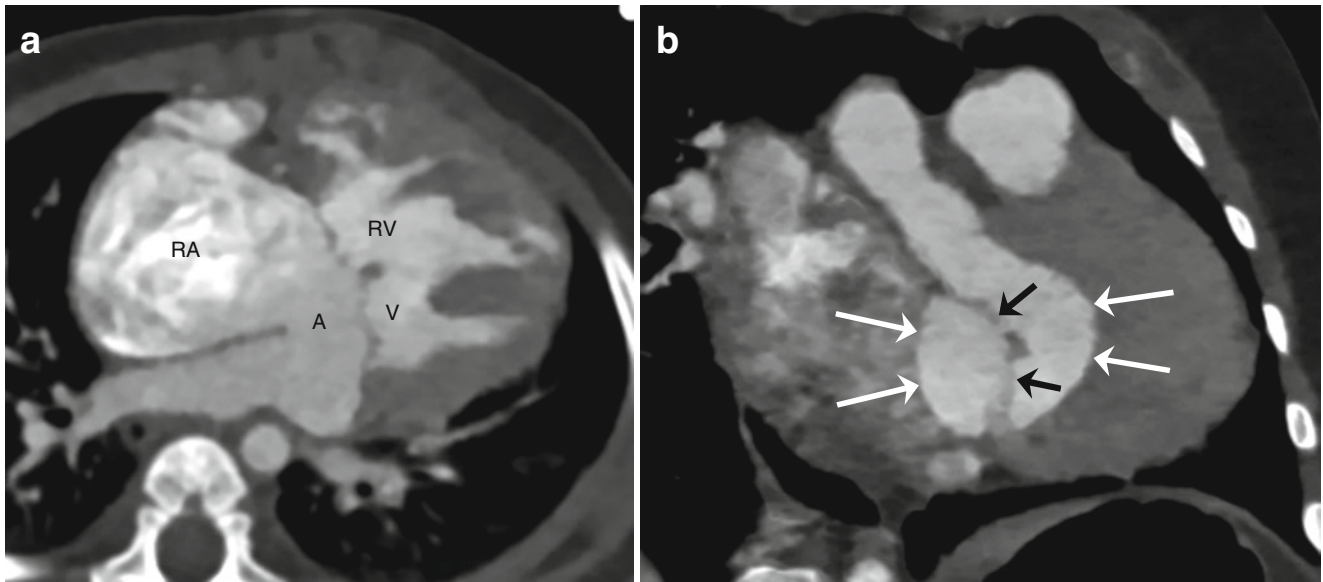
Atrioventricular septal defect. Four-chamber CT image shows an atrioventricular septal defect consisted of a primum atrial septal defect (A) and an inlet ventricular septal defect (V) (a). The right atrium (RA)
